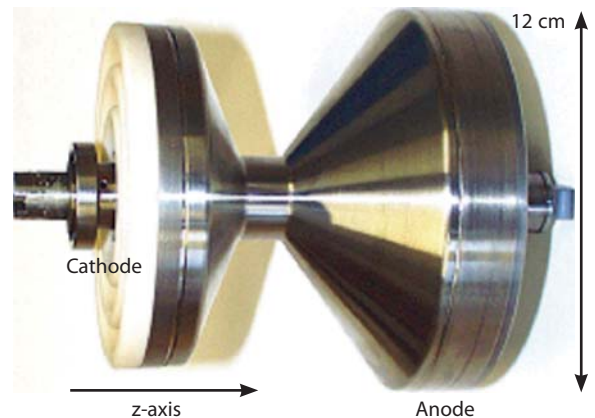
A rotating-envelope X-ray tube (STRATON tube, Siemens, Forchheim, Germany). The tube design is very compact; the anode diameter is only 12 cm
